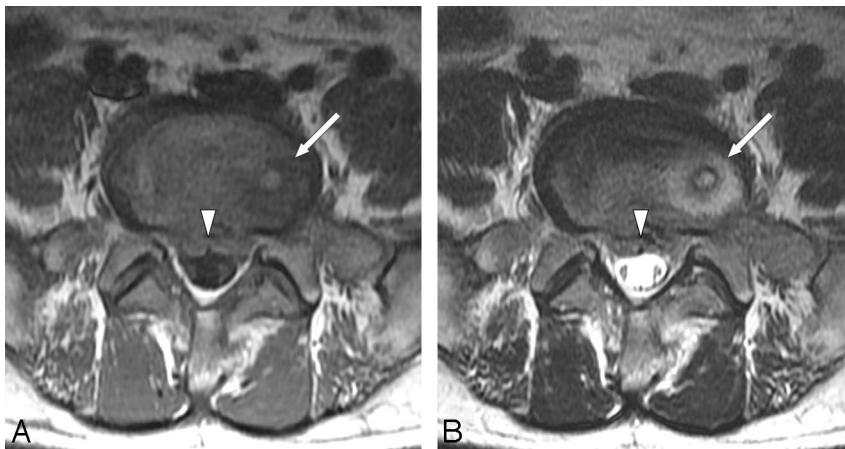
A 42-year-old man experienced low-back pain and fever for 5 days. *A* and *B*, Axial T1-weighted (TR/TE, 600/16) (*A*) and axial T2-weighted (TR/TE, 4900/111) (*B*) MR images show an intraosseous lesion of T1-weighted low signal intensity and T2-weighted high signal intensity with an inner rim sign and an outer halo sign (arrow) near the upper endplate of S1. Note the limited amount of epidural soft-tissue inflammation (arrowhead).
